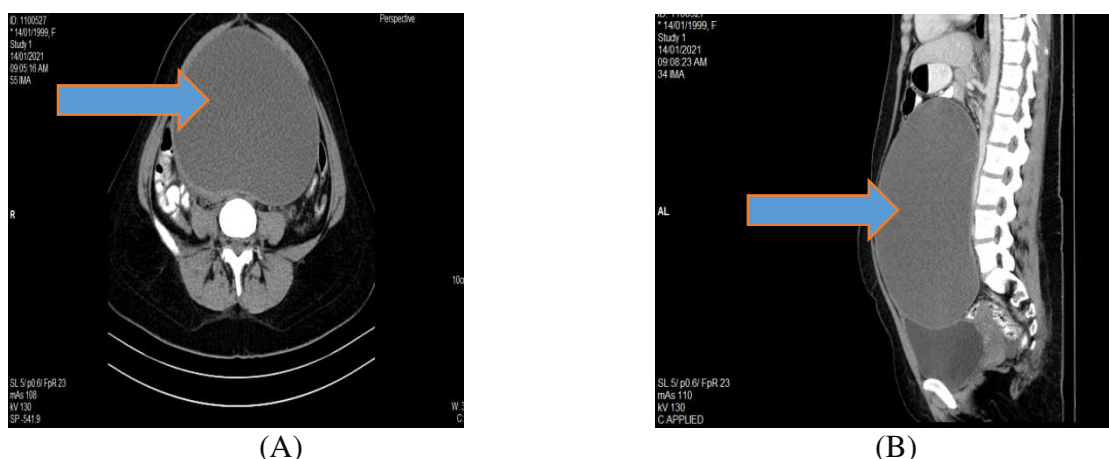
(A) Axial CT Abdomen with contrast (B) Coronal CT abdomen with contrast shows a large abdominopelvic cystic mass Arrows.
